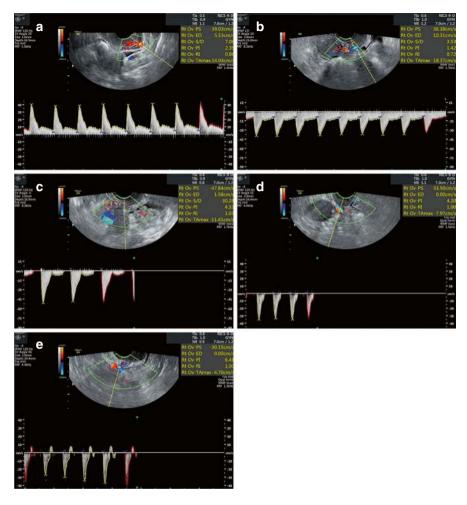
(a) Type C uterine artery blood flow. (b) Type C uterine artery blood flow. (c) Type A uterine artery blood flow. (d) Type O1 uterine artery blood flow. (e) Type O2 uterine artery blood flow. Note: The direction of the wave represents the direction of blood flow—toward the ultrasound probe or away from it
